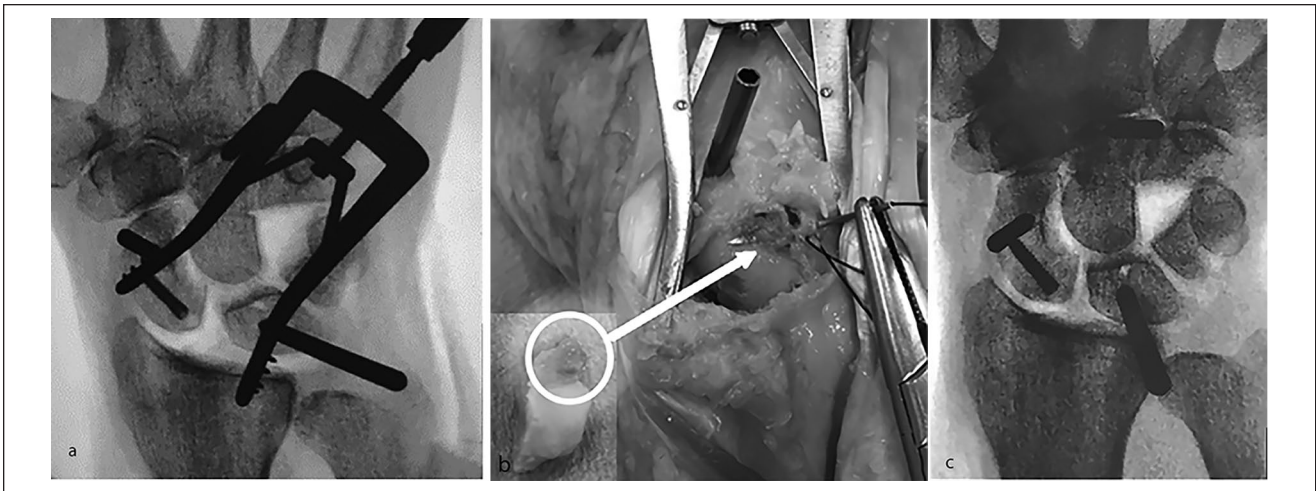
(a) Anteroposterior radiograph after proximal hamate pole fixation with a compression screw showing a persistent scapholunate gap. (b) Reconstruction of the dorsal scapholunate ligament with the volar capitolunate ligament. (c) Anteroposterior radiograph with screw fixation of the hamate and reconstruction of the scapholunate ligament showing reduction of the scapholunate gap.
